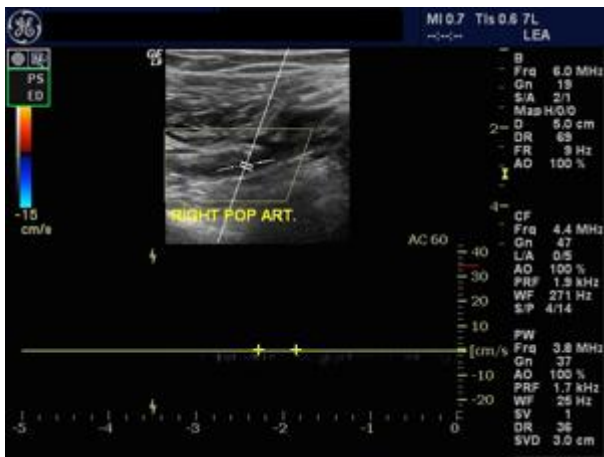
Color and Spectral Doppler image of Right Popliteal Artery.
